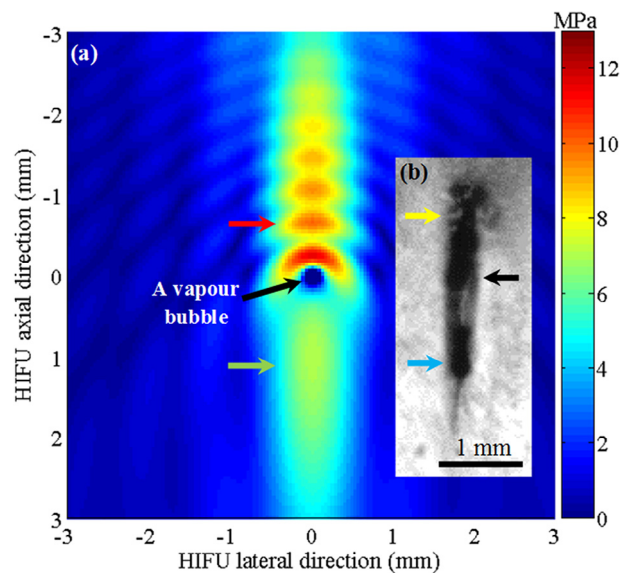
(a) Calculated acoustic pressure magnitudes resulting from the scattering of the HIFU field by a boiling bubble. The presence of partially shielded acoustic pressure field behind the vapor bubble (green arrow). The backscattered pressures (red arrow). The HIFU beam propagates from top to bottom. (b) High-speed image showing a cavitation cluster (yellow arrow) in front of and a secondary boiling bubble (blue arrow) behind the primary boiling bubble (black arrow). HIFU = high-intensity focused ultrasound.
